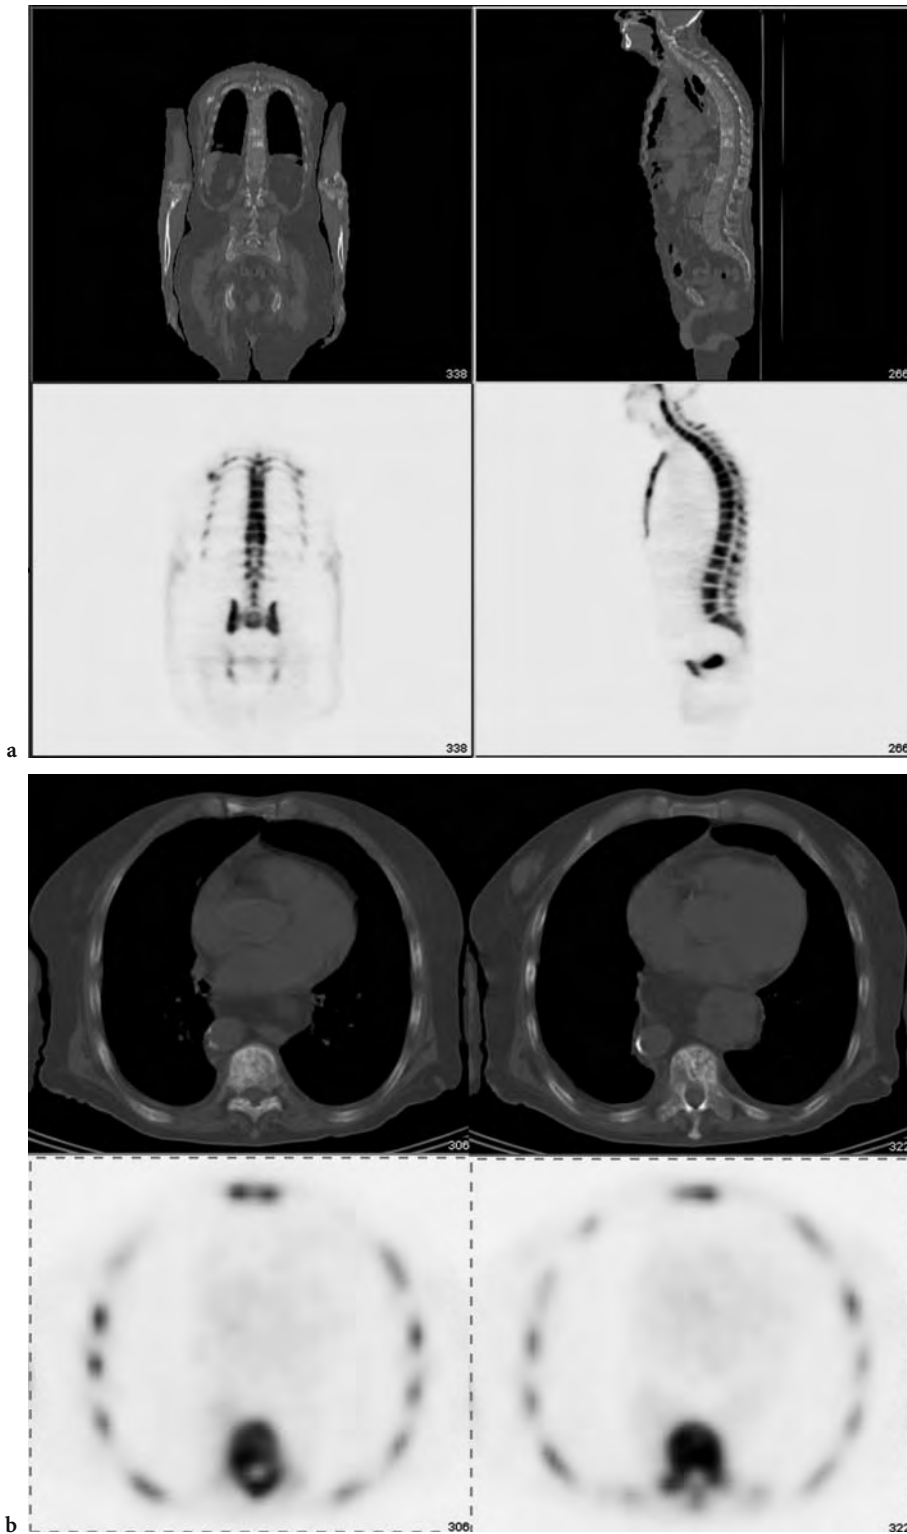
^{18}F -Fluoride PET/CT images of an 82-year-old man with hormone refractory prostate cancer. a Coronal (*left*) and sagittal (*right*) planes of the CT (*top row*) and PET (*bottom row*). b Axial cuts of the chest at two different levels, T8 (*left panel*) and T9 (*right panel*). Note the difference between CT abnormality and the corresponding PET abnormality. T8 has minor uptake whereas T9 uptake involves a much larger part of the vertebral body. These findings suggest a more sclerotic lesion in T8 and active disease involvement in T9
